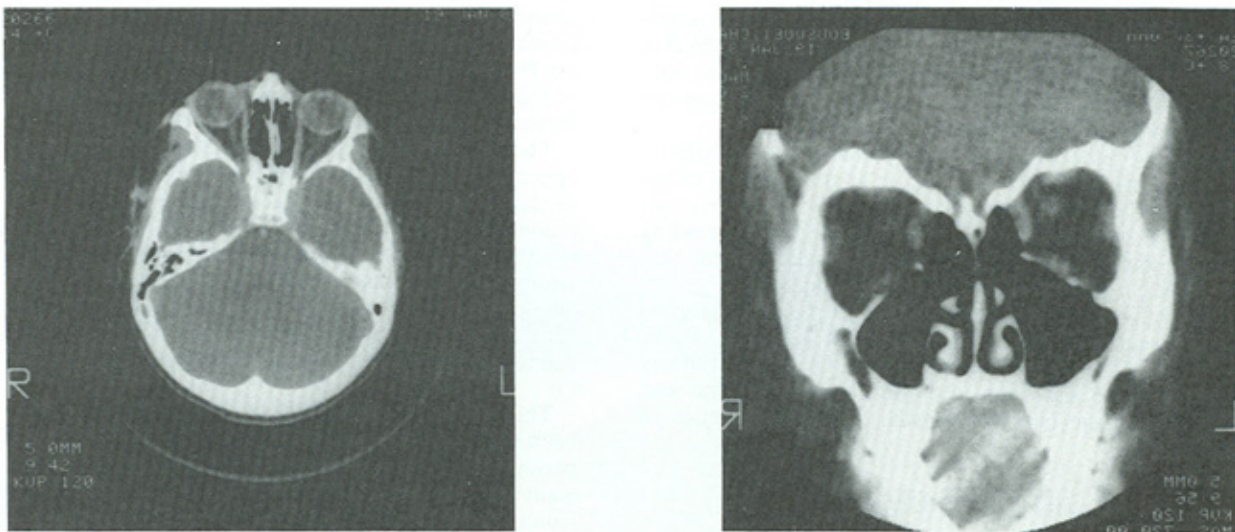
Computed tomographic scan performed 2 months postoperatively demonstrating the absence of an orbital tumor.
